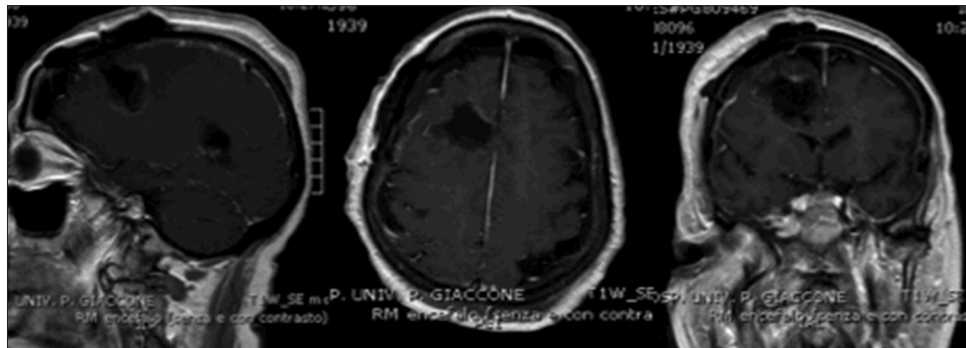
Postoperative neuroimaging of a right frontal glioblastoma. Gadolinium enhanced T1 weighted brain magnetic resonance imaging (MRI)
